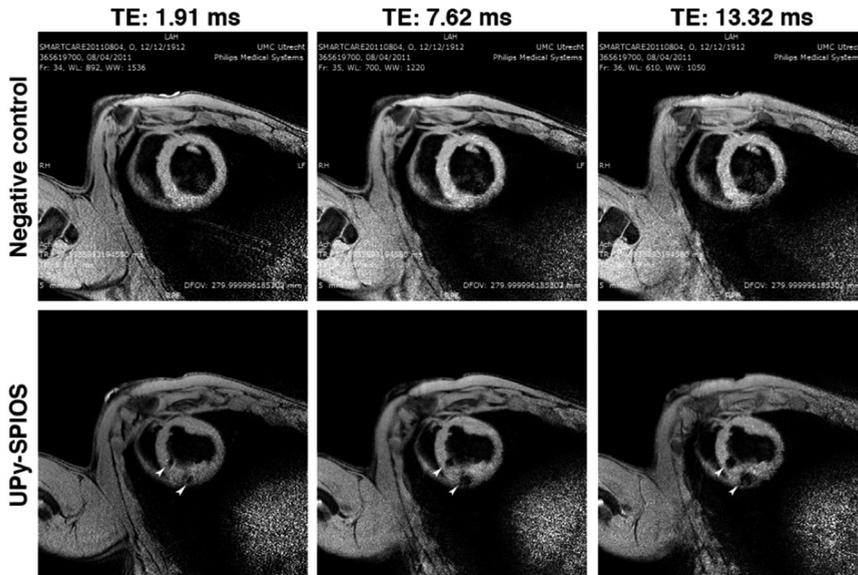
Figure SI-8: Visualization of SPIOS by T2* cardiac MRI. Representative T2* MRI images of a healthy heart (negative control) and a heart in which two NOGA injections of UPy-hydrogel labeled by SPIOS (depicted as UPy-SPIOS) have been placed. These UPy-SPIOS injections are visible as black dots of increasing intensity as echo time increases (white arrows). TE denotes Time to Echo.
